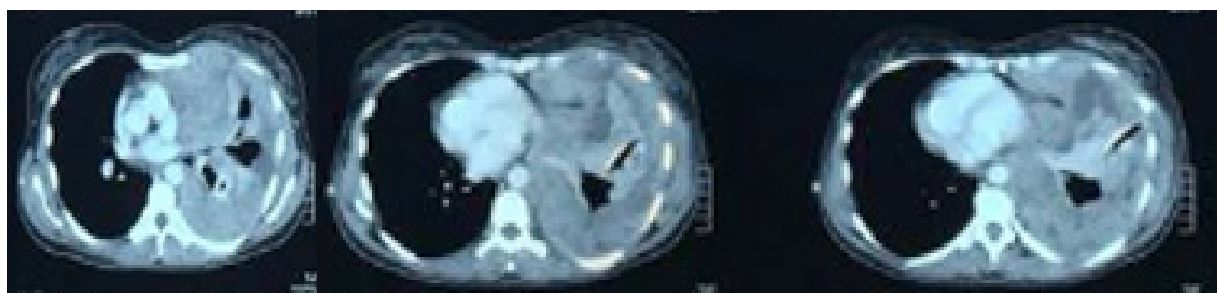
Computed tomography of thorax showed left pleural mass with effusion
